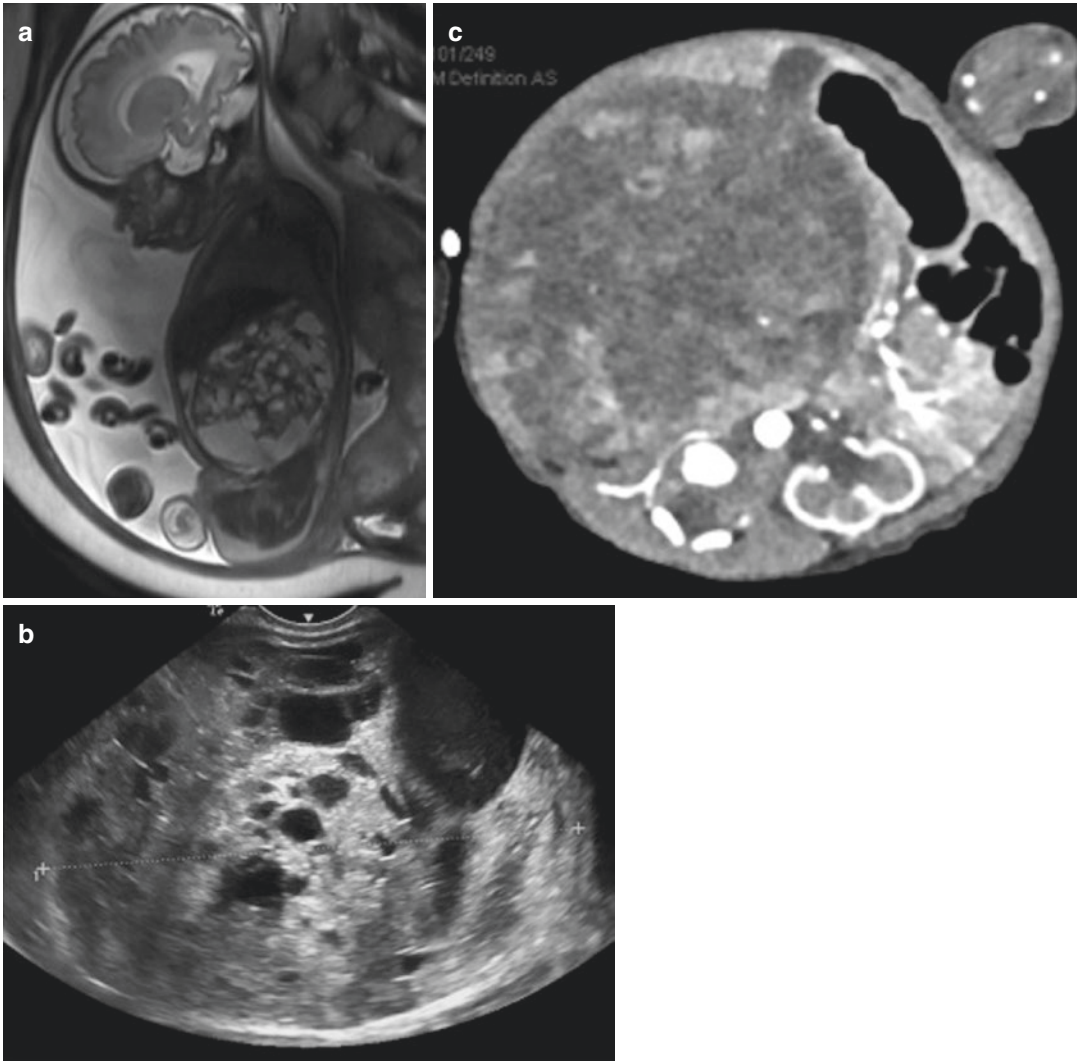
Pre- and postnatal assessment of a mesoblastic nephroma. (a) Sagittal T2 weighted MR imaging of a 35-week-old fetus with hydramnios demonstrating a very large heterogeneous abdominal mass. (b) Neonatal US confirms the heterogeneous mass that almost completely
